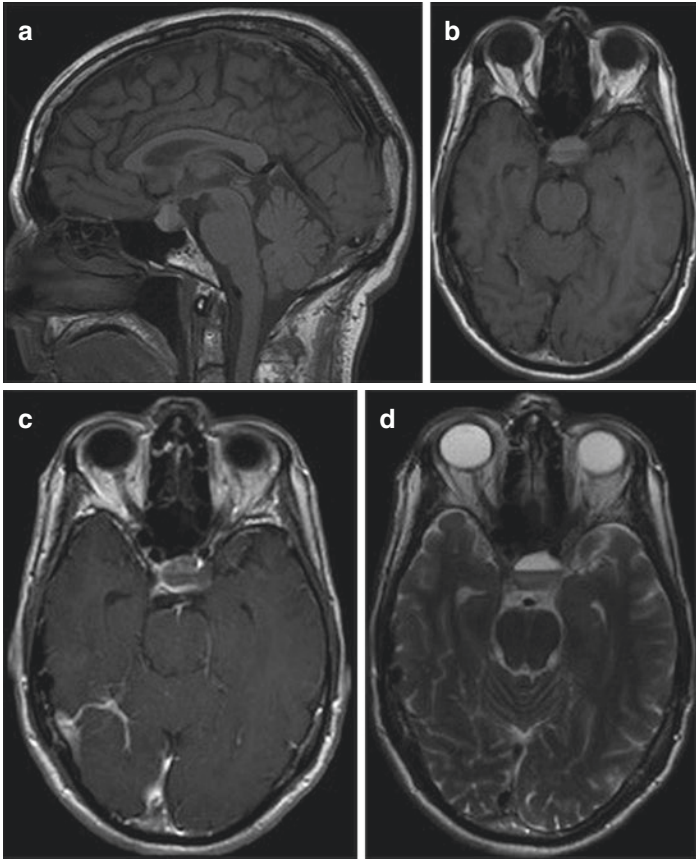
MRI of a patient with pituitary apoplexy. Images were obtained approximately 24 hours after onset of symptoms (sudden headache, nausea, vomiting, and fatigue). Images show enlargement of the pituitary gland, which contains a fluid hematocrit level. (a) T1 sagittal, the upper margin of the pituitary gland is contacting and slightly displacing the optic chiasm superiorly. (b) Axial pre-contrast. (c) T1 axial post gadolinium. (d) T2 axial
